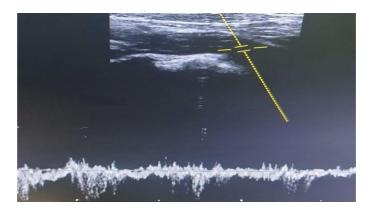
Venous flow on pulsed Doppler
